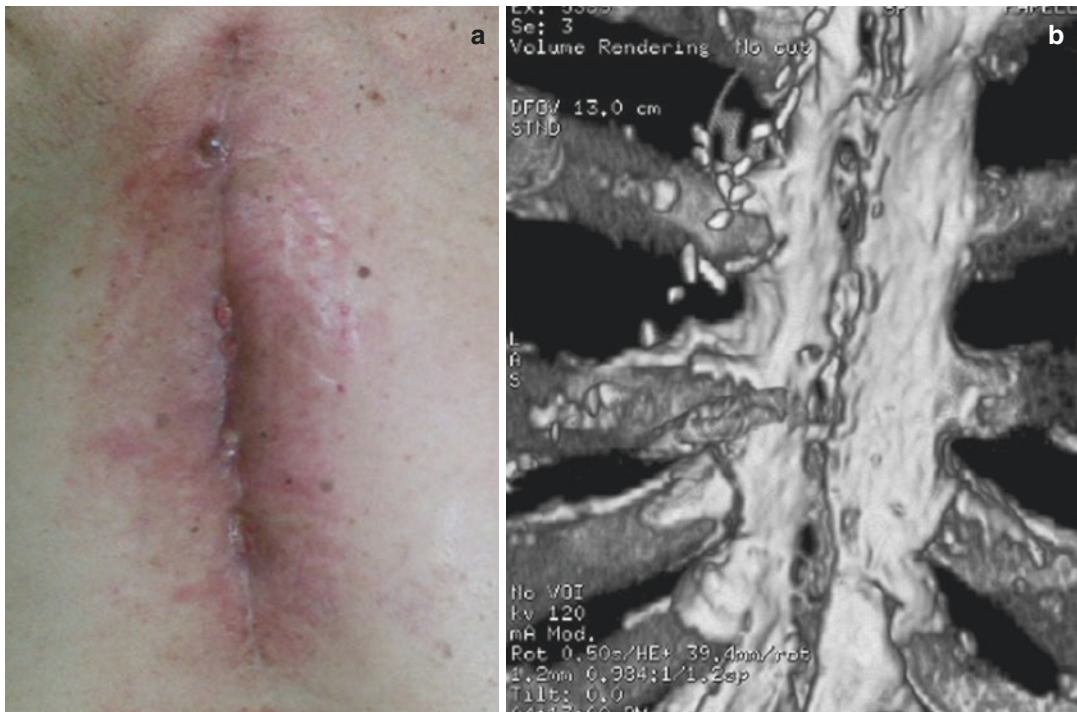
Sternum-cutaneous fistula outlined by 3D chest CT
